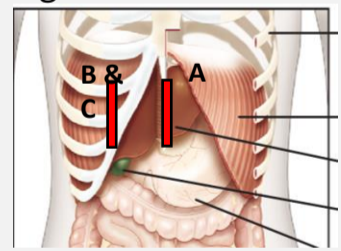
Ultrasound Probe Placements
